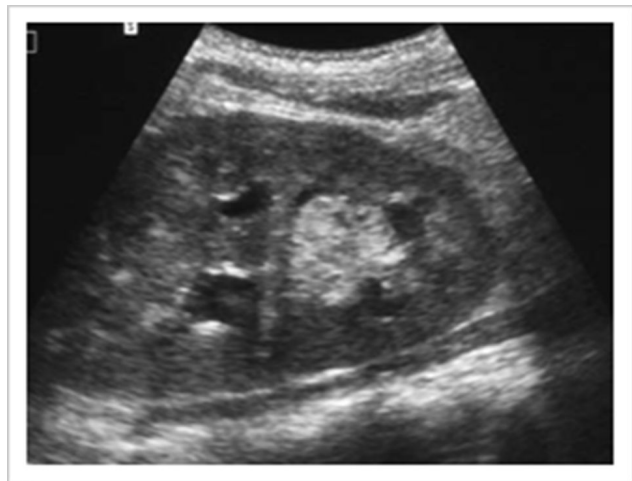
Ultrasound picture of graft pelvis partial obstruction by fungal mass.
